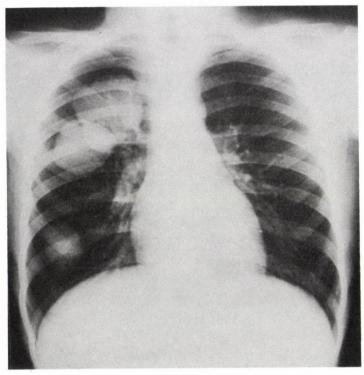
P-A X-Ray: image of three cysts in the right lung
